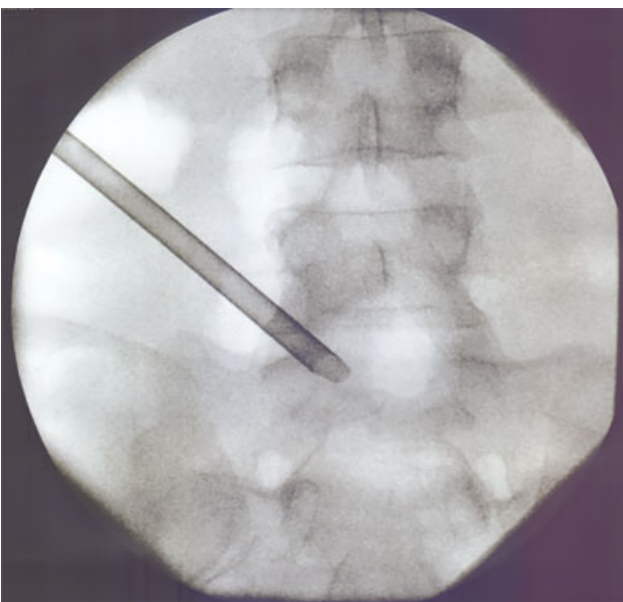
Intraoperative anteroposterior radiographic visualization of the working cannula at level L5–S1 with its opening just medial to the pedicle.
